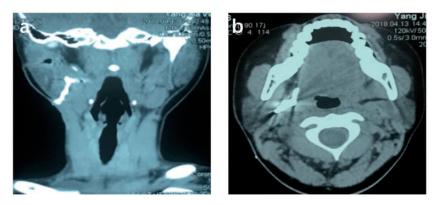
Computed tomography images of fistula. (a) Coronal view. (b) Horizontal view.
